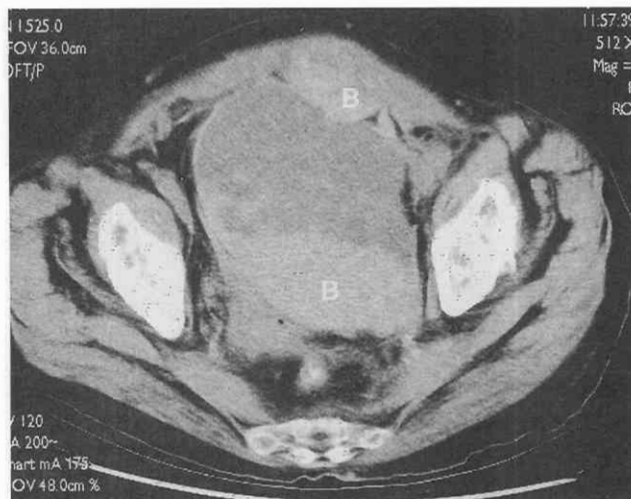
Pelvic hematomas. CT scan through the pelvis shows high-density blood (B) within the left rectus abdominis muscle and layering out in the left pelvis in an extraperitoneal location. This elderly patient had taken an overdose of anticoagulant therapy.
